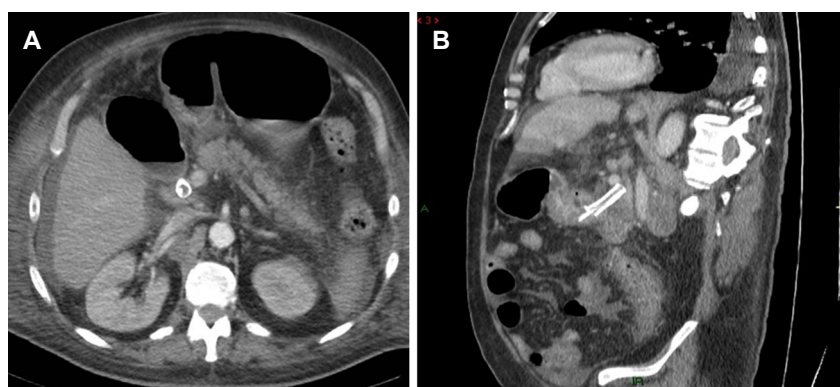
Control CT-scan on (A) axial plane and (B) sagittal reconstruction showing both plastic and metal stents in place
